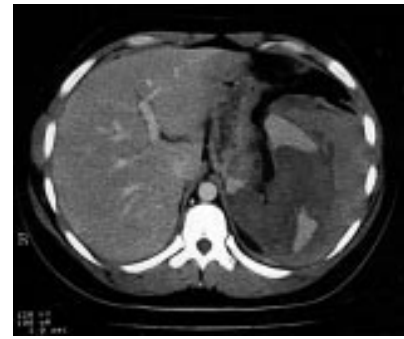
Abdominal computed tomogram.
